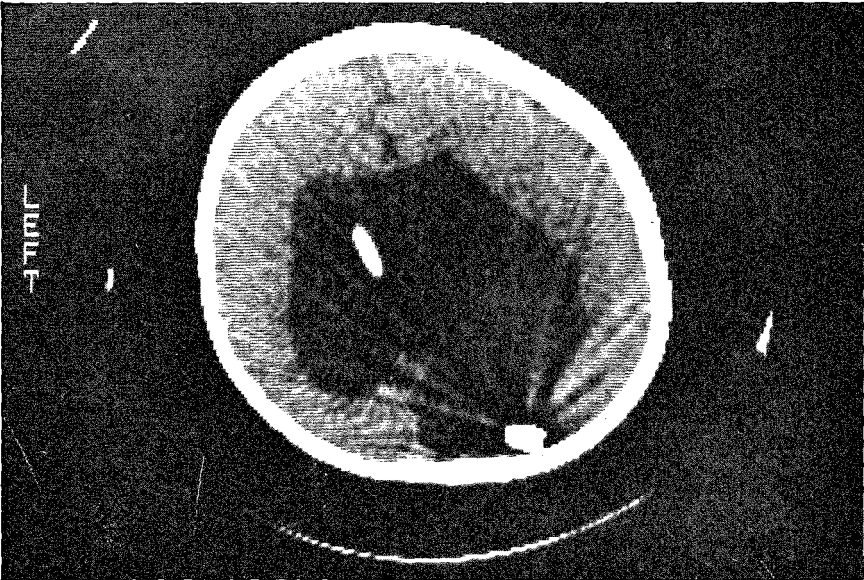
CT scan showing the metallic component corresponding to the Hakim's valve just within the porencephalic cyst.
